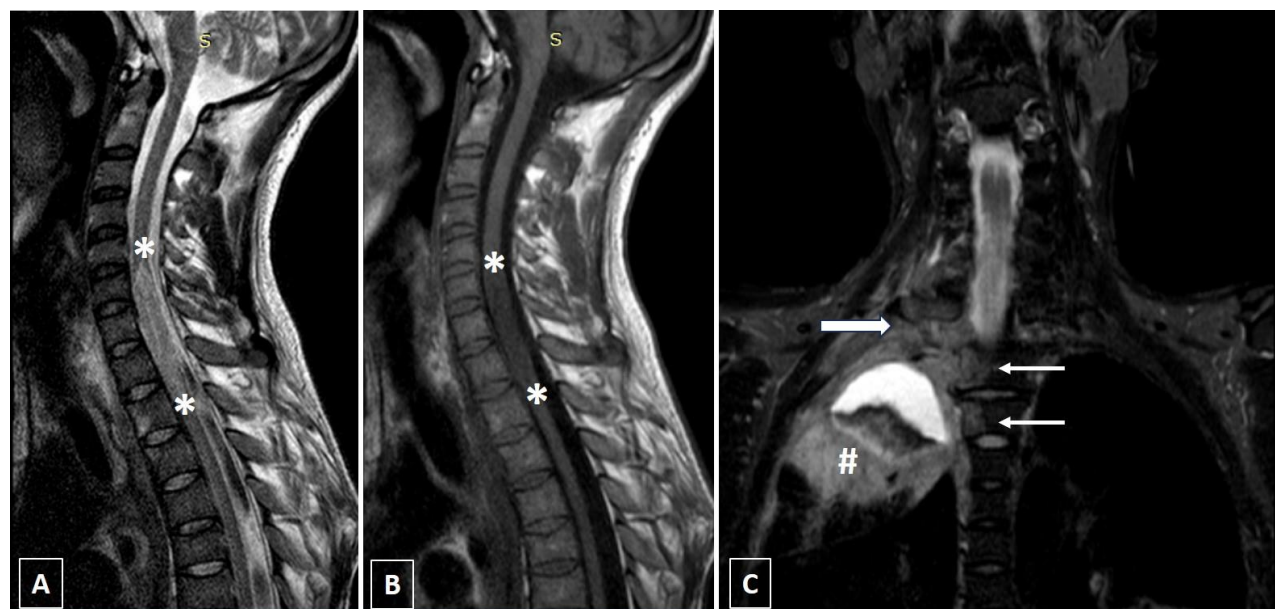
Panel of MRI images: (A) T2-weighted, (B) T1-weighted sagittal images of the cervical spine reveal swollen and edematous cord (white asterisks) from C5 to D2 vertebrae. (C) STIR coronal image shows consolidation with cavitation in the right lung apex (#), contiguous soft tissue oedema of the ipsilateral chest wall extending to paravertebral soft tissues (thick white arrow), and marrow oedema along the right side of the vertebrae (thin white arrows).
